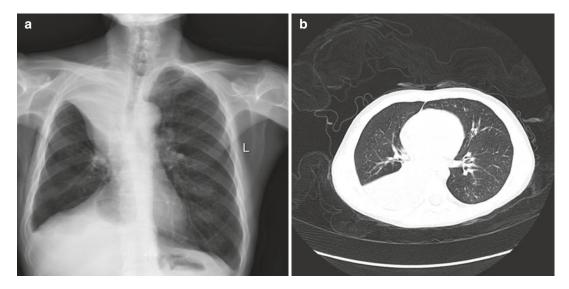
Images of atelectasis; chest X-ray (a) and chest CT image (b)
